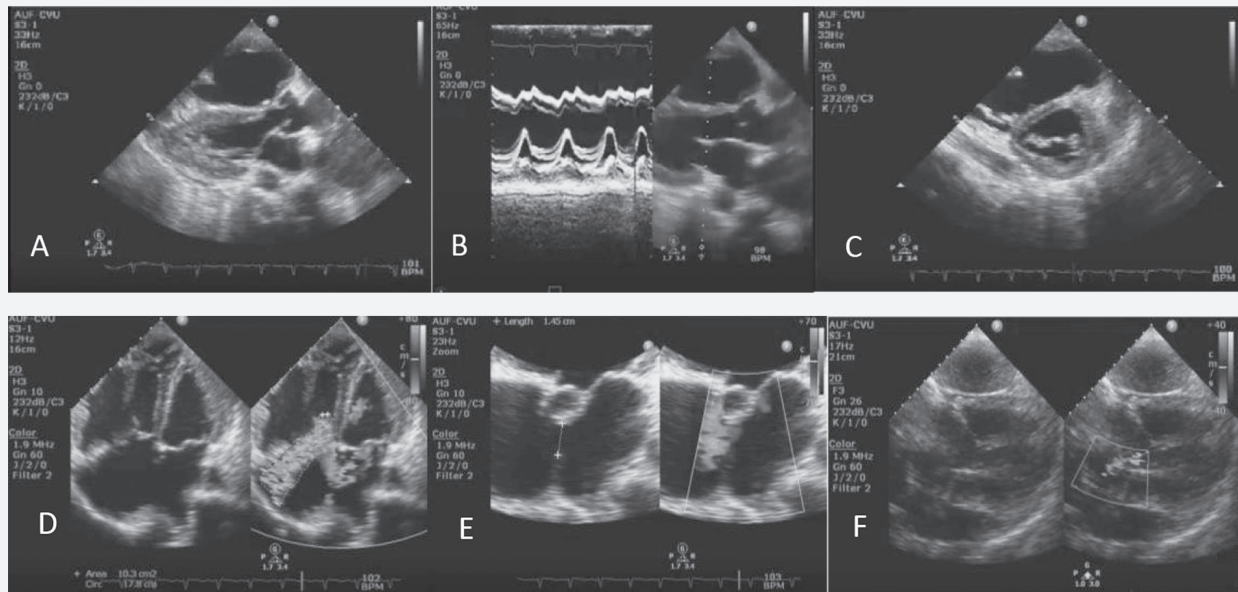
Transthoracic echocardiogram. A, PLAX view: the anterior mitral valve leaflet is thickened at the tip, with subtle diastolic doming motion; the commissures, however, are not yet fused. B, M-mode: showing sclerosis of the anterior mitral leaflet. C, PSAX mitral valve level: possible mitral stenosis, with thickened anterior mitral valve leaflet. D, Apical 4-chamber view: ASD, large secundum type: abnormal color flow noted across the interatrial septum, secundum type. Moderate to severe tricuspid regurgitation: mosaic color flow noted across tricuspid valve (jet area = 10.3 cm², vena contracta = 0.60 cm) during systole. E, Apical-5 chamber view: ASD, large secundum type: abnormal color flow noted across the interatrial septum, secundum type with defect measuring 1.4 cm in its widest diameter with a predominantly left-to-right shunt with Qp/Qs of 5.9:1 using flow across the RVOT and LVOT (RVOT VTI = 12 cm, LVOT VTI = 9.6 cm). F, Subcostal view: ASD, large secundum type: abnormal color flow noted across the interatrial septum, secundum type. LVOT=left ventricular outflow tract; PLAX=parasternal long-axis view; PSAX=parasternal short-axis view; RVOT=right ventricular outflow tract; VTI,=velocity time integral.
